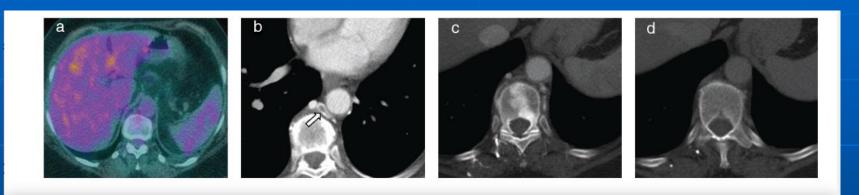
(a-d) Non-contrast positron emission tomography CT centred at the site of previous abnormal vertebral body attenuation demonstrates no 18-fludeoxyglucose-avid metastatic disease with the abnormal attenuation in question no longer apparent (a). Review of the prior contrast-enhanced CT scan in question (b-d) revealed subtle thrombus in the hemiazygos vein (arrow) with much of the abnormal attenuation centred in the basivertebral veins (c). On delayed phase, the abnormal attenuation has resolved (d). Collapse
